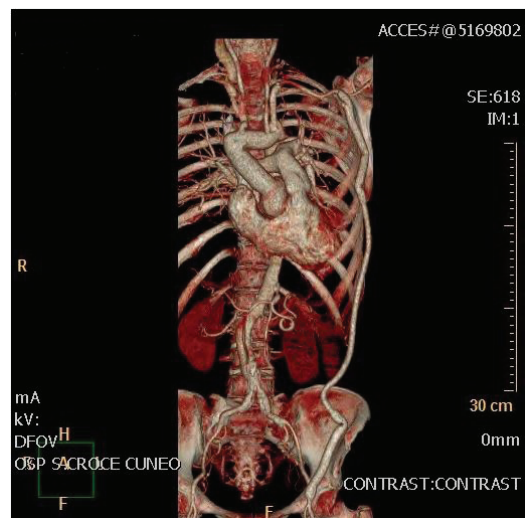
Postoperative 3-dimensional computed tomography imaging of thoraco-abdominal aorta and left axillo-femoral bypass graft.
